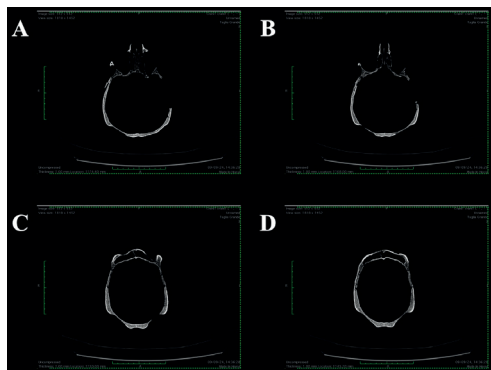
CT scan of individual in the axial plane, coronal vision. A) Extreme thinning is noted in the right parietal bone, with the absence of diploe and the fusion of the outer and inner tables; B) Progressive thinning of the parietals, with the junction of the outer and inner tables also noted in the left parietal bone; C) Progressive thinning of the parietals, with a taphonomic hole visible in the left parietal bone; D) Stage of thinning in which progressive absence of diploe and fusion of the outer and inner cortices is noted in the right parietal bone
